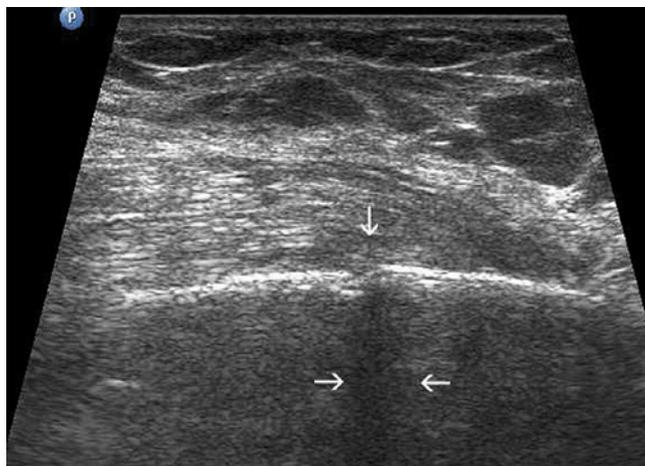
Dislocated rib fracture, causing chimney phenomenon on ultrasound (arrows)
